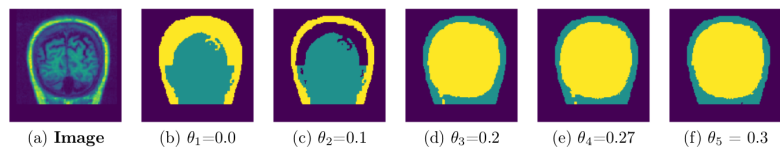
A representative coronal section from 3D MRI showing the separation of components for different thresholds: MRI from a single subject (IBSR data set) experimented using different thresholds and nodes sample size is 20,000. GUBS is run on 3D and for visualization we take 2D at the same location for all experiments.
